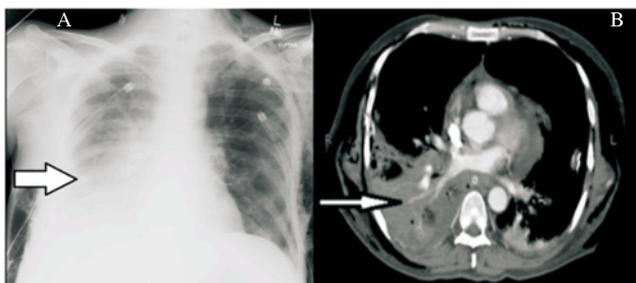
Left 1A: Chest X ray AP view shows right lower lung zone opacification; Right 1B: CT scan chest shows right lower lobe consolidation.
